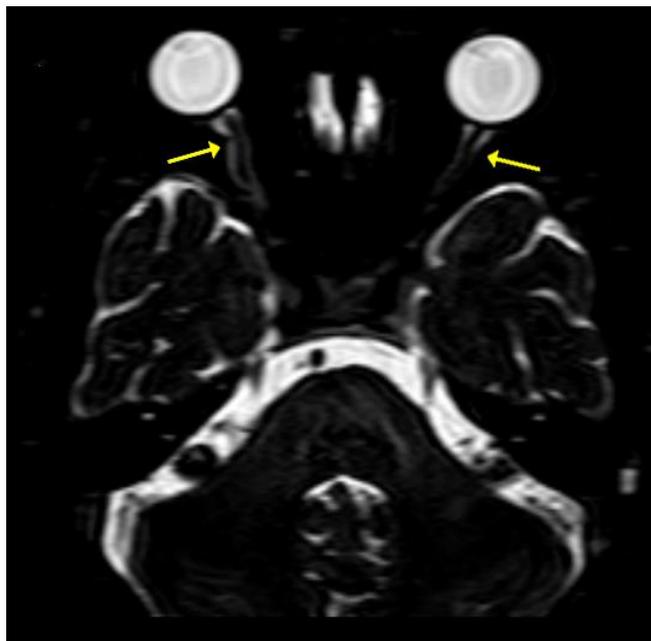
Non-contrast T2 weighted MRI of the brain showing prominent cerebrospinal fluid surrounding bilateral mildly tortuous optic nerves with flattening of bilateral posterior sclera, suggestive of bilateral papilledema
